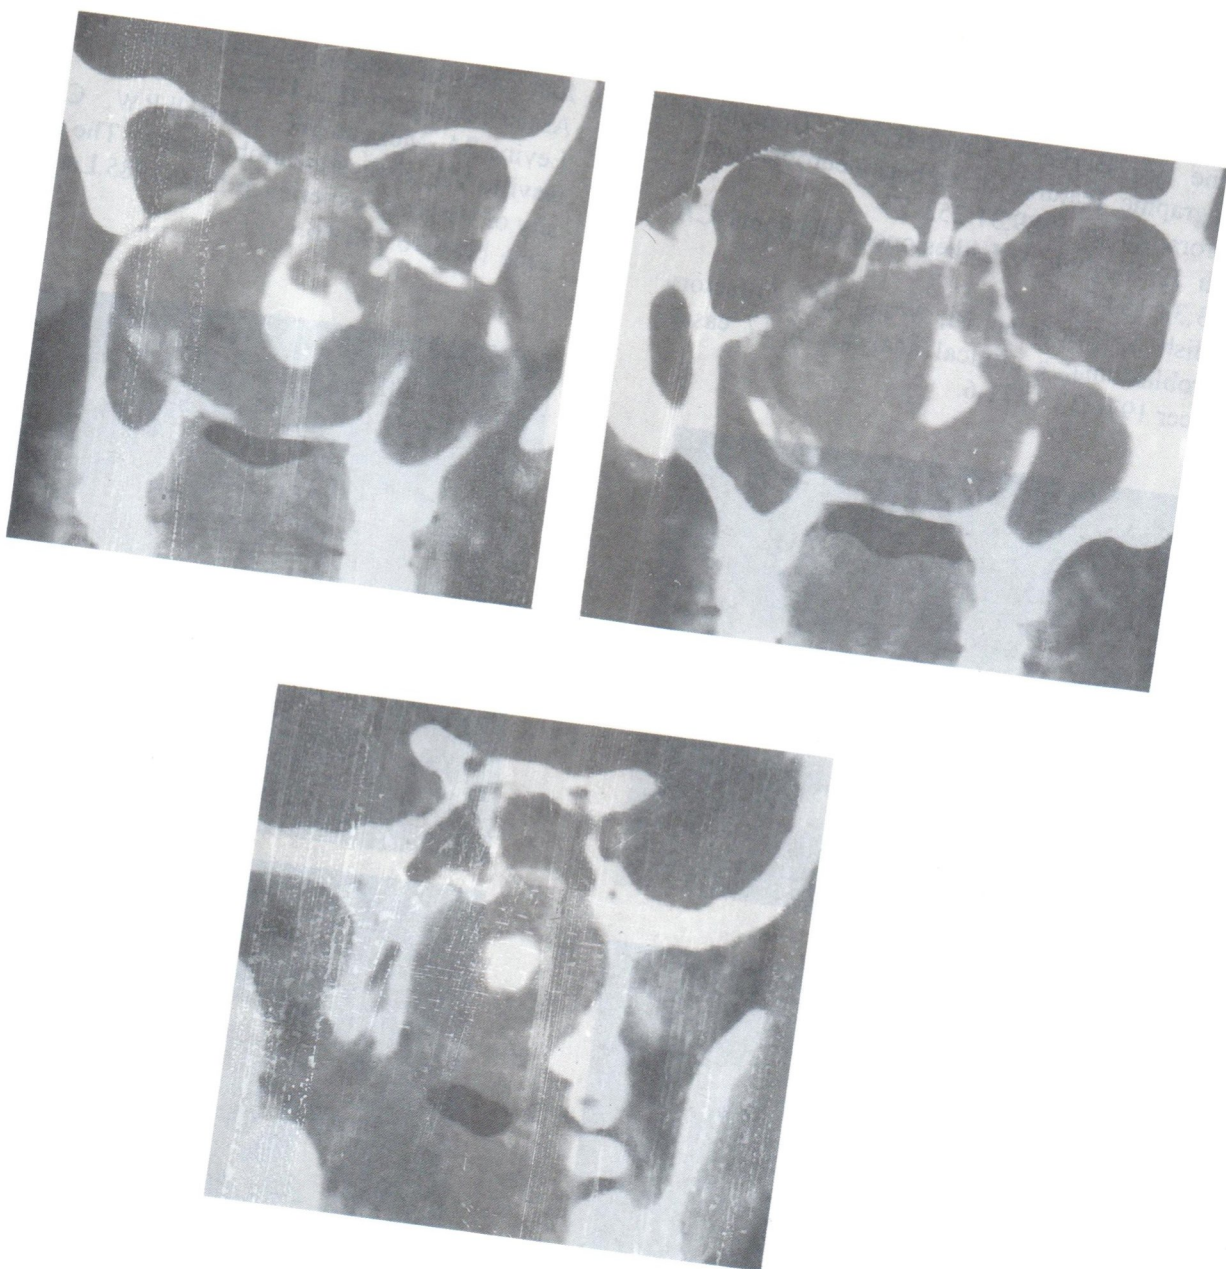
Coronal view enhanced CT scan of the mass
